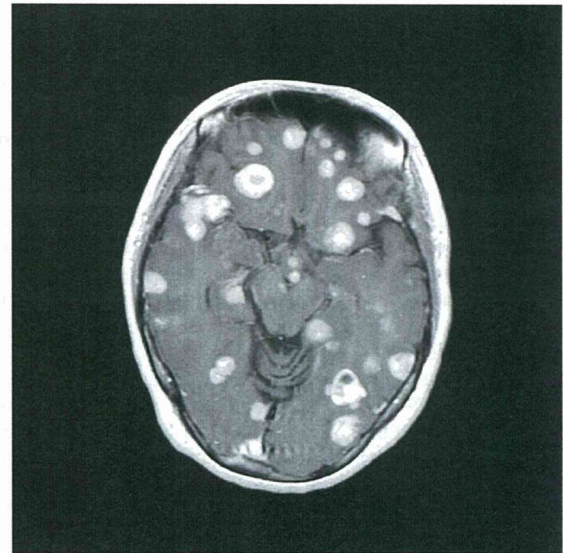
Brain MRI of case 2 on 7/30/2010 showing multiple metastases.
